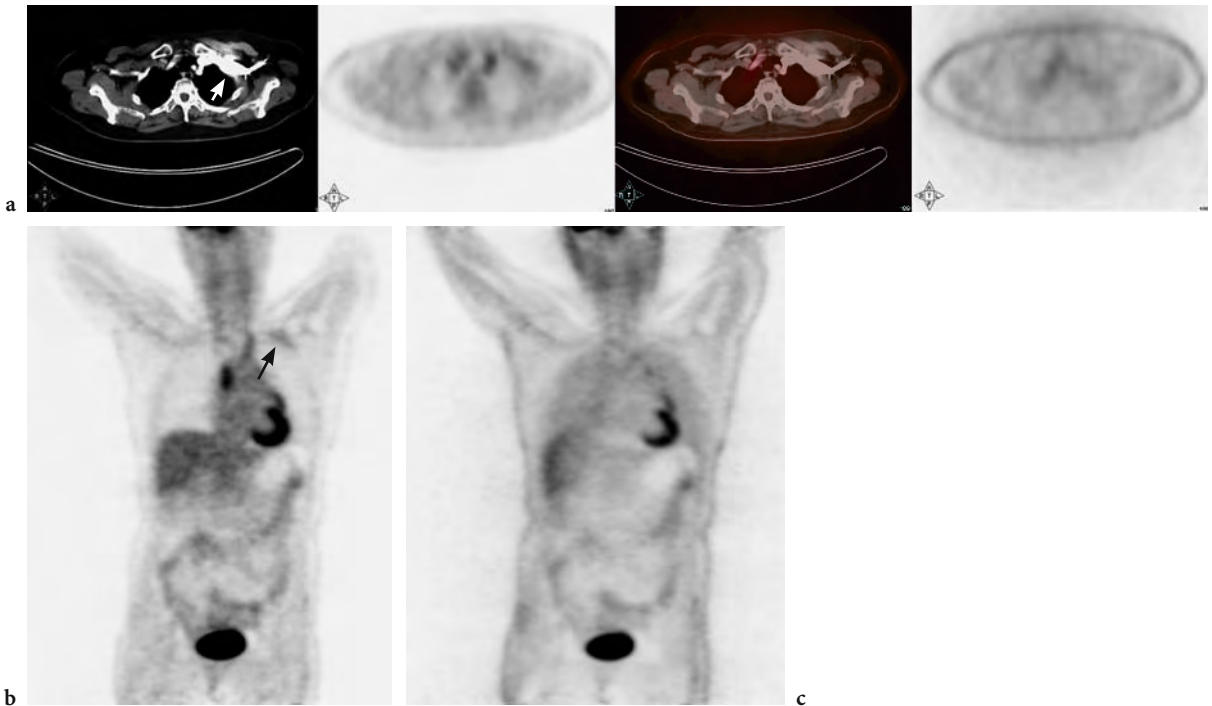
a Axial images of a 67-year-old female referred for re-staging of colon cancer, 2 years after curative resection. *Left panel*, CT image in the soft tissue window, with intra-venous contrast in the left subclavian region (*white arrow*). *Second panel left*, PET image with mildly increased uptake in the left subclavian area, related to over-estimation of the attenuation coefficients due to the contrast. *Second panel from right*, fused axial images, CT in gray scale and PET in color. *Right panel*, PET image not corrected for attenuation shows normal uptake in the left subclavian region. b Coronal PET image shows the mildly increased uptake (pseudo FDG uptake) in the left subclavian region (*black arrow*). c In the uncorrected image this is not present, indicating that the “uptake” is an attenuation correction artifact
